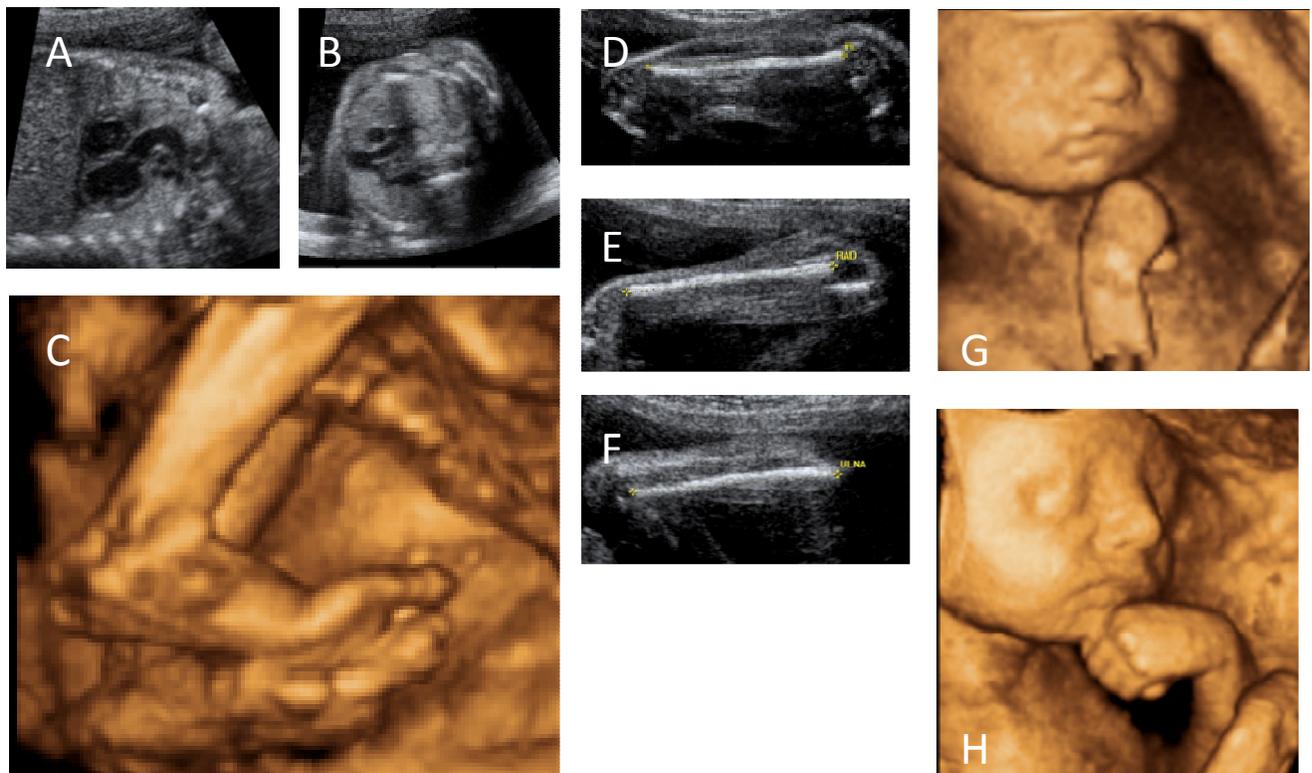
24w4d Ultrasound
